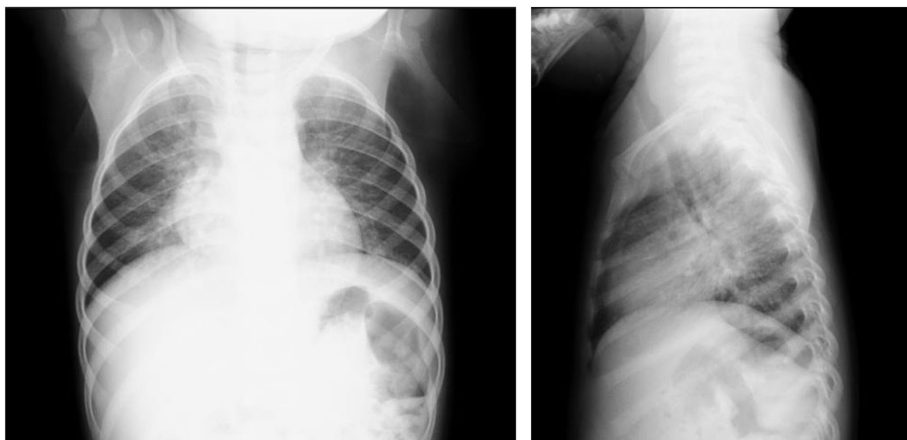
Frontal and lateral chest radiographs showed diffuse bilateral bronchial wall thickening, consistent with an inflammatory or infectious bronchial process.
